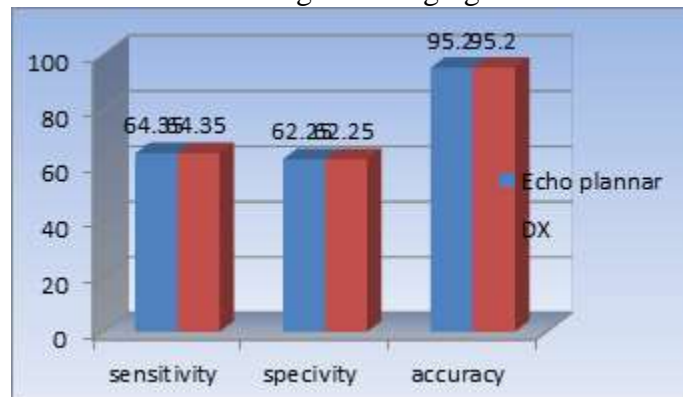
The figure above indicated the sensitivity, specificity, and accuracy of technique echo planar imaging of MRI
